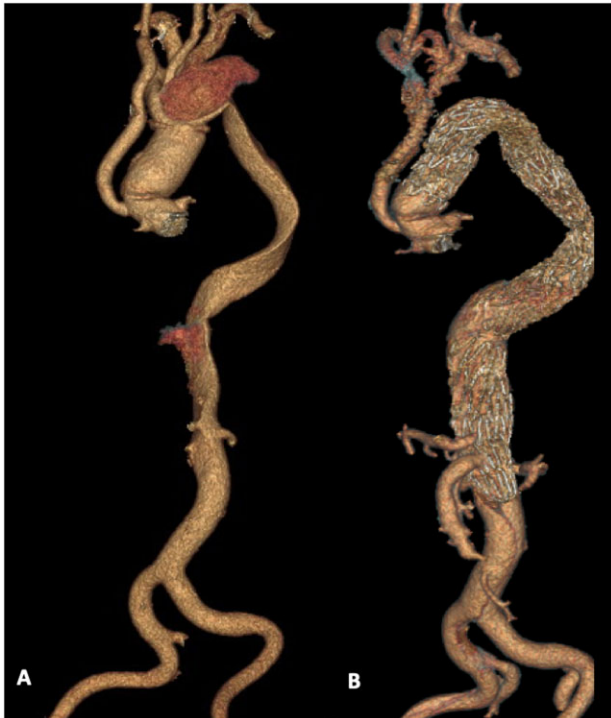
Hybrid repair for aneurysmal evolution of residual aortic dissection. (A) CT scan after TAAD repair with IA debranching; (B) intrathoracic complete supra-aortic trunk debranching and endoprosthesis implantation in zone 0.
